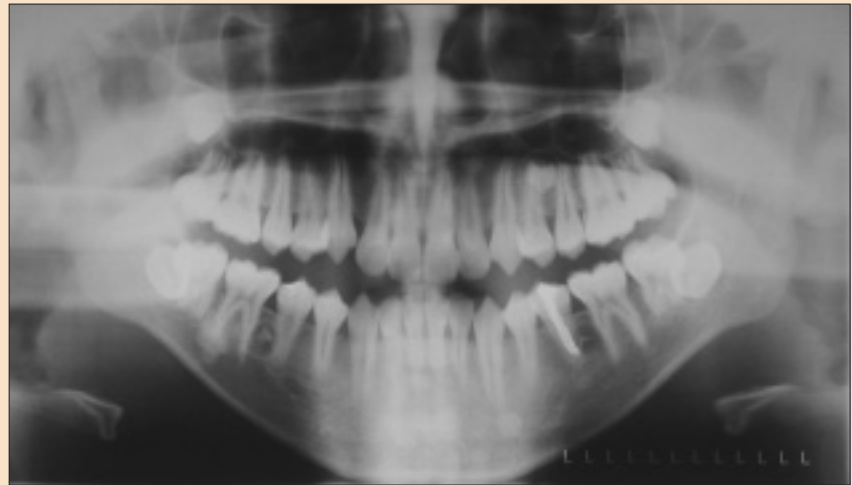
Orthopantomogram shows supernumerary premolars in quadrant 2, 3 and 4.
